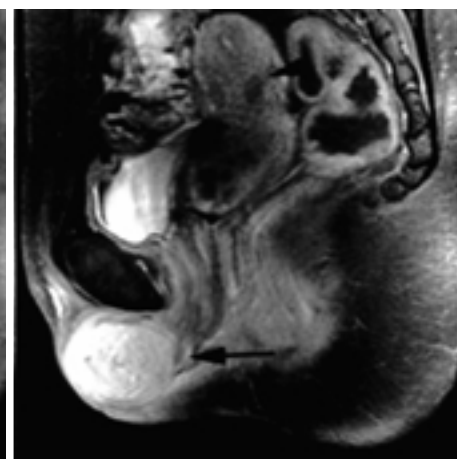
A. On sagittal T1-weighted MR image (TR/TE 1108/12), the mass (arrow) is slightly hyperintense to the myometrium (arrowhead).
